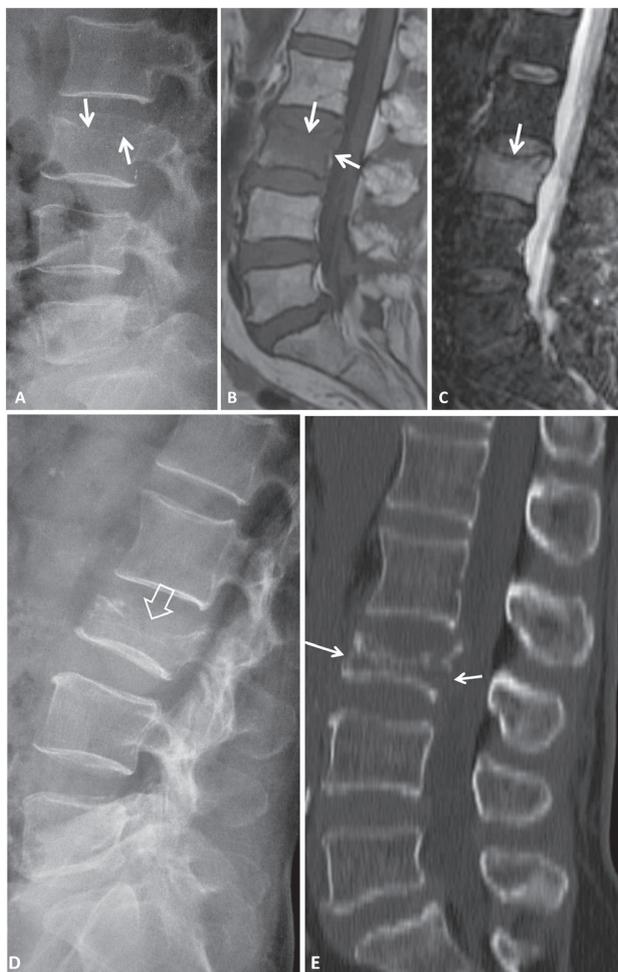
A 67-year-old female patient with primary spinal non-Hodgkin lymphoma, presenting with low back pain. The lateral radiograph (A) shows mild osteopenia in the upper L3 vertebral body, with suspicion of mild collapse of the upper epiphyseal plate (arrows). The sagittal T1w (B) and STIR (C) MR images show to better advantage the almost complete infiltration of the bone marrow of L3 vertebral body and collapse of the superior epiphyseal plate (arrows). Two weeks after the initial imaging investigation, a non-traumatic pathologic fracture is shown on plain radiograph (arrow) (D). Sagittal reconstruction CT (E) shows to better advantage the compressive pathologic fracture (arrows).
